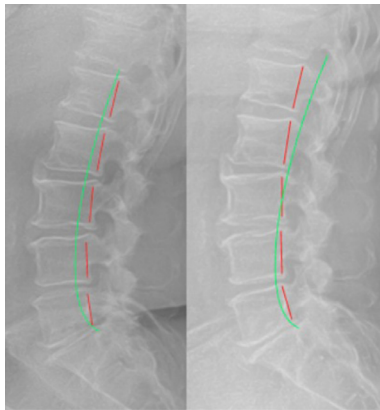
Lateral lumbar radiographs. Left: Initial (Oct. 16, 2017) showing hypolordosis and overt osteoarthritis particularly from L2–S1. Right: Follow-up (May 3, 2018) showing increase in lordosis after treatment.
